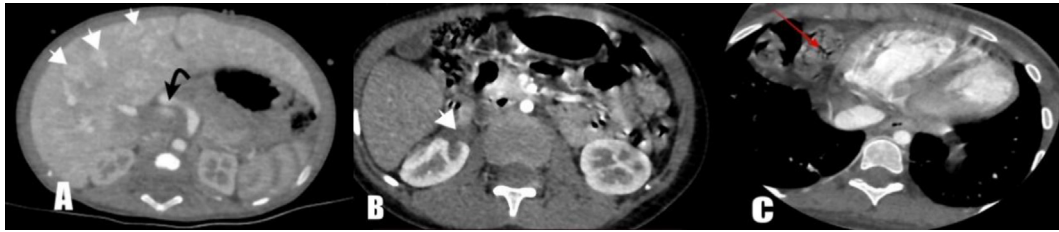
Example of Abdominal findings: (a) A 6 month male patient with persistent pulmonary hypertension, axial multi-slice computed tomography scan of the abdomen shows multiple enhancing hepatic focal lesions (arrowheads) associated with dilated intrahepatic vessels, dilated hepatic artery (curved black arrow) and dilated celiac trunk. Pathologically proven hemangioendothelioma. (b) A well-defined peripheral edge shaped area in the right kidney (arrowhead) impressive of renal infarction. (c) Axial multi-slice computed tomography showing a large Morgagni hernia with herniated intestinal loops (red arrow) into the right hemithorax. MSCT: multi-slice computed tomography.
